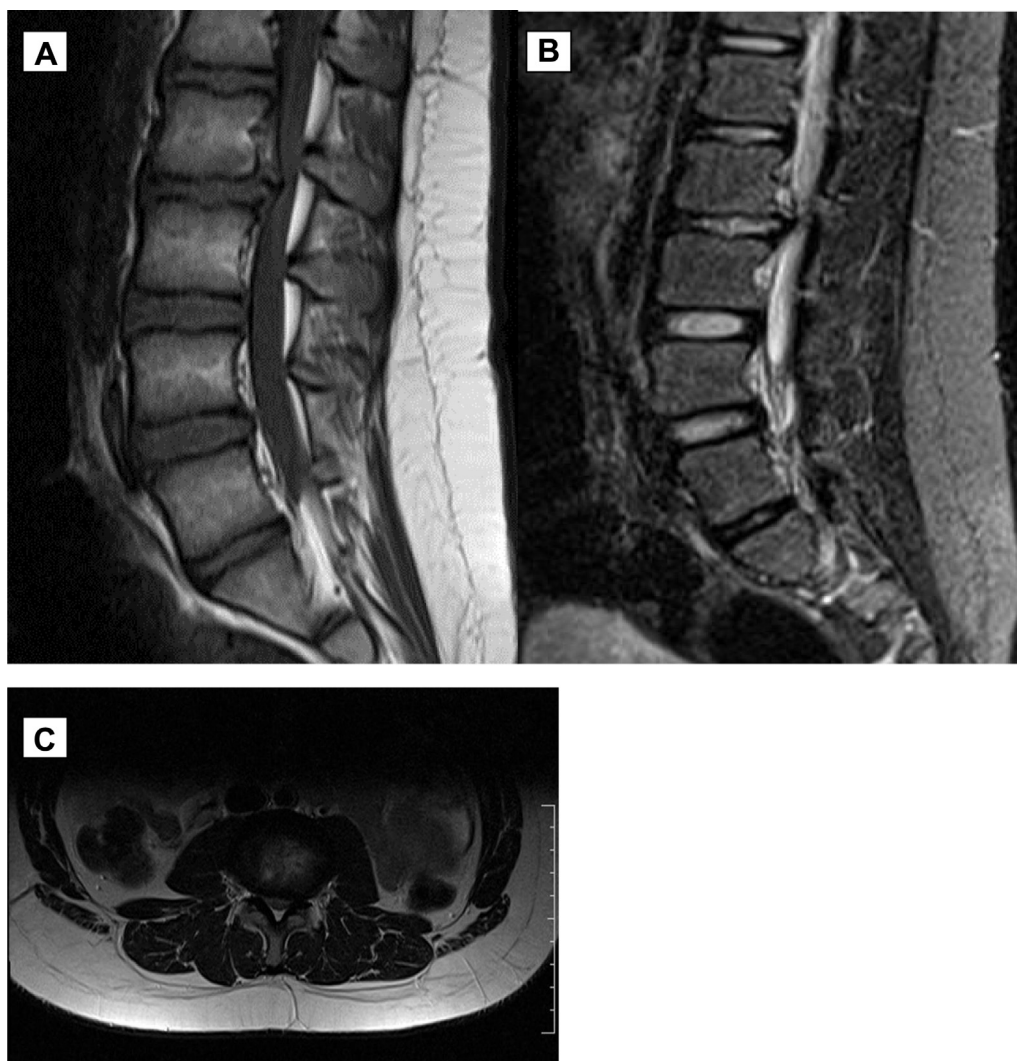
T1 weighted (A) magnetic resonance imaging (MRI) image of the lumbar spine in sagittal plane shows a disc bulge at L2-L3 level. A defect with a small suspicious hypointense structure is seen along the posterior aspect of the inferior end plate of the L2 vertebral body. The disc material is seen herniating superiorly through this defect. Short tau inversion recovery (STIR) (B) image shows mild marrow hyperintensity in adjacent bone due to acute fracture. T2 weighted axial image (C) shows disc bulge producing mass effect on contained nerve roots at this level.
